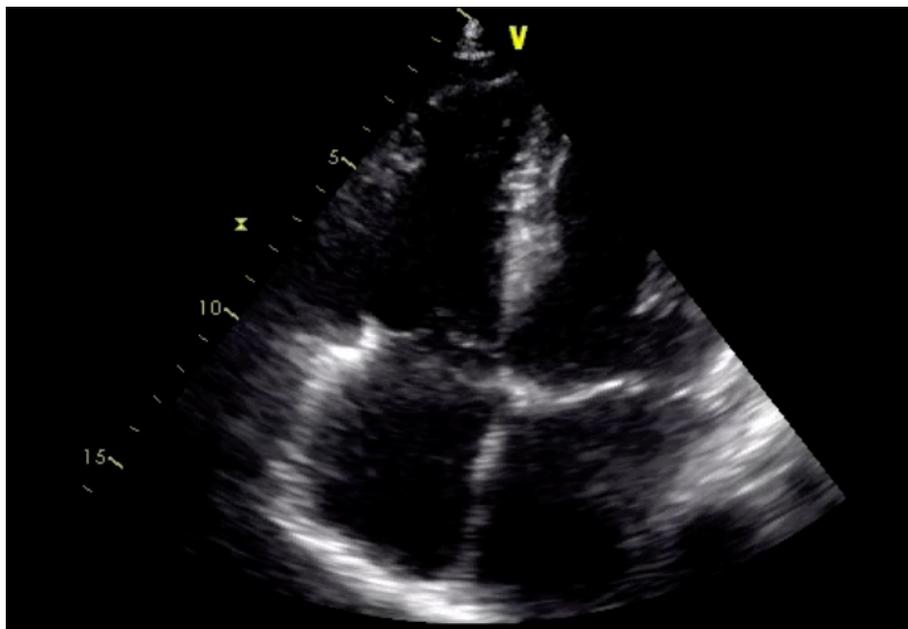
Apical Four Chamber Echocardiogram View: A focal dyskinetic bulging in the apical segment of the right ventricle is evident.
